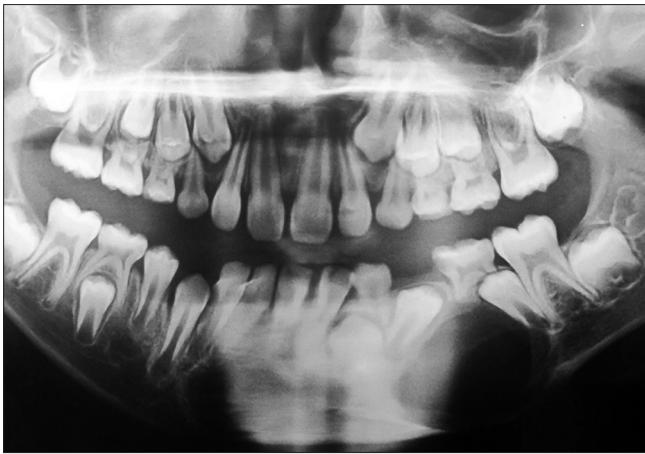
Radiolucency with sclerotic border from mesial of tooth 36 to distal of 3C in the panoramic radiograph
